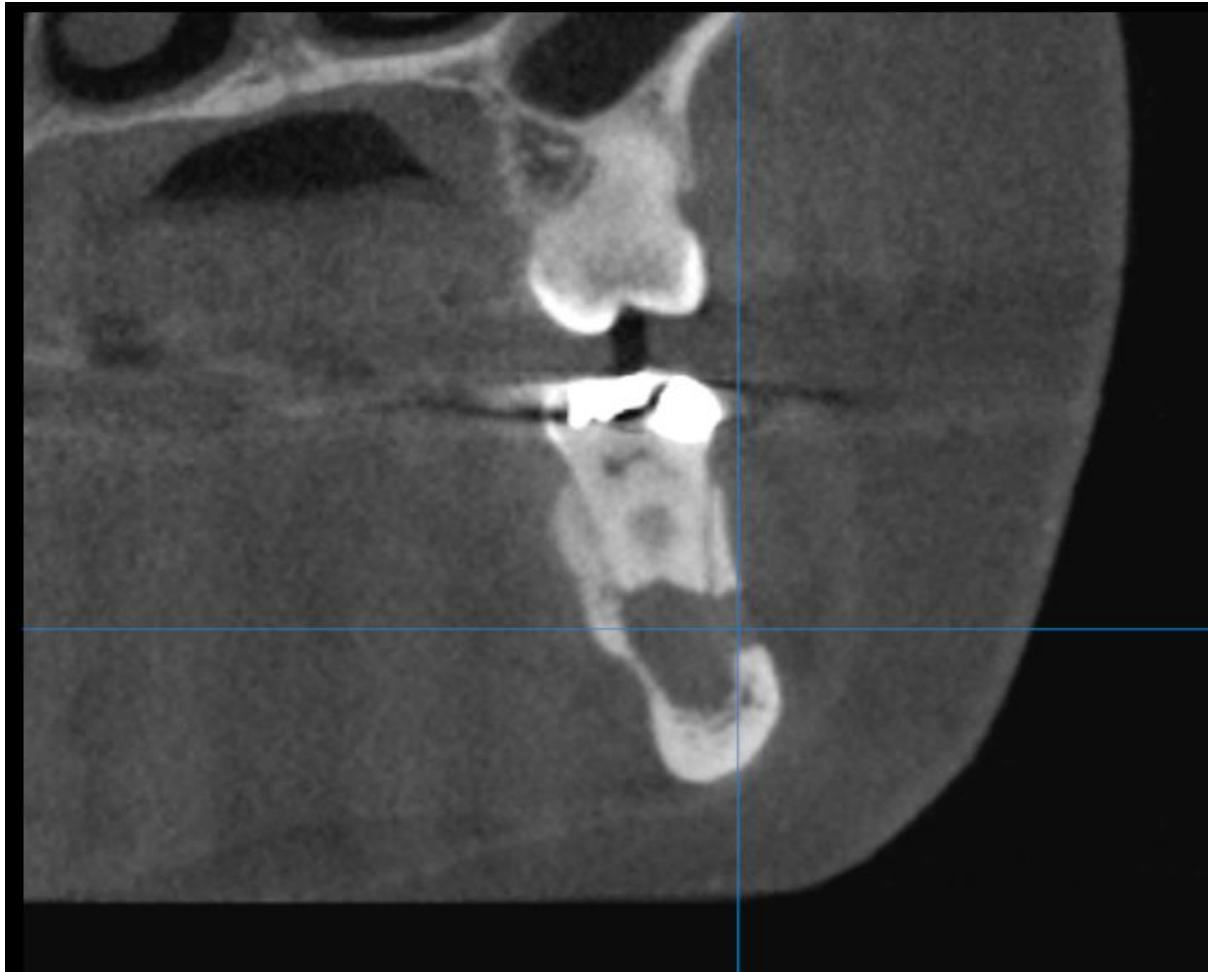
CBCT coronal of schwannoma in left mandible near the mental foramen.
